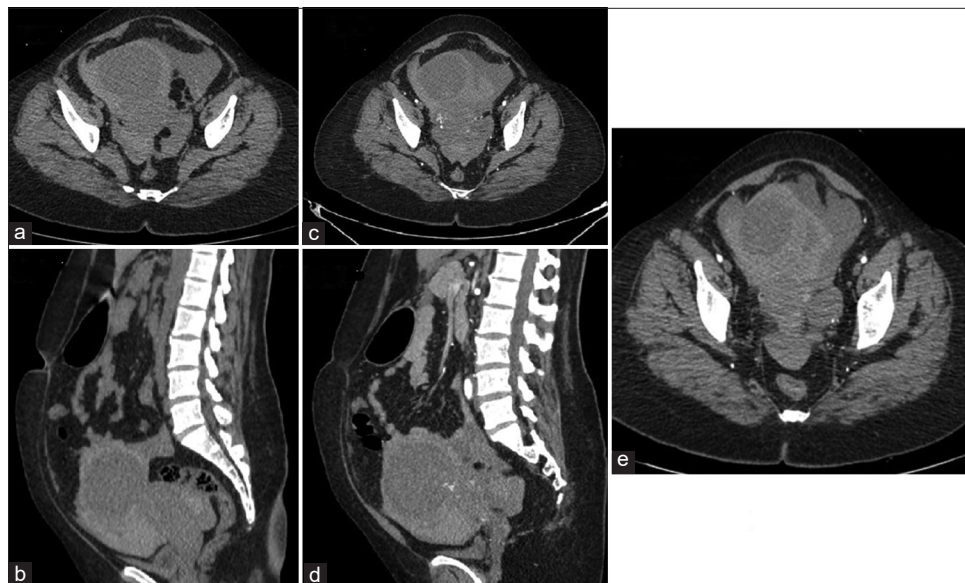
Non-contrast computed tomography (CT) (a) axial and (b) sagittal section at the level of pelvis revealed well defined, pedunculated sub-serosal isodense mass lesion noted, arising from the anterior aspect of uterine fundus. Contrast-enhanced CT arterial phase, (c) axial and (d) sagittal section at the level of pelvis shows moderate enhancement with prominent dilated vessels noted within the lesion. No active arterial contrast extravasation was noted. Contrast-enhanced CT arterial phase, (e) axial section shows moderate pelvic collection with internal hyperdense contents noted suggestive of hemorrhage.
